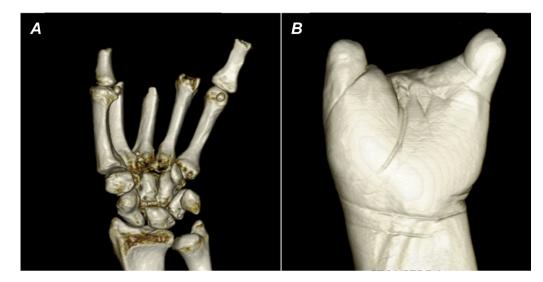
(A) Bone structure of the remaining limb taken from a computed tomographic scan. The amputation levels correspond to thumb, proximal phalanx, second and third transmetacarpal, fourth metacarpophalangeal joint, and fifth proximal phalanx. (B) Three-dimensional reconstruction of involved soft tissue and skin.
